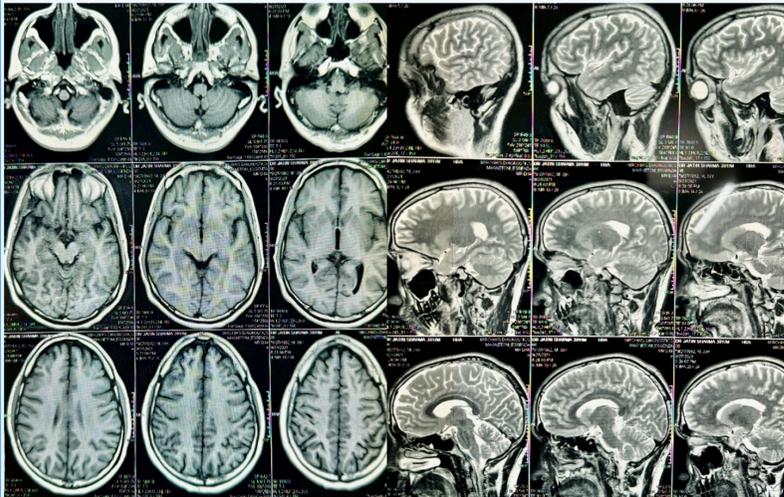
MRI Reports Post Injury shows Normal Brain Imaging
